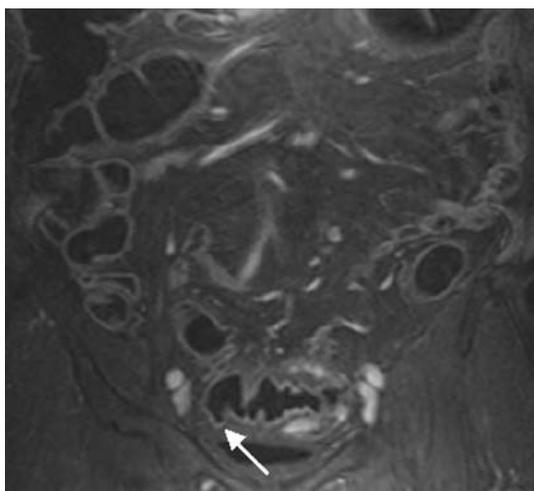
Coronal source image of a T1-weighted gradient-echo three-dimensional MR image from 60-year-old woman with suspected sigmoid diverticulitis. Dark lumen MRC using a volumetric interpolated breath-hold examination sequence (TR/TE 3.1/1.1 ms, flip angle 12°, matrix 168×256) was acquired after intravenous administration of contrast medium showing multiple diverticula of the sigmoid colon (*arrow*)
